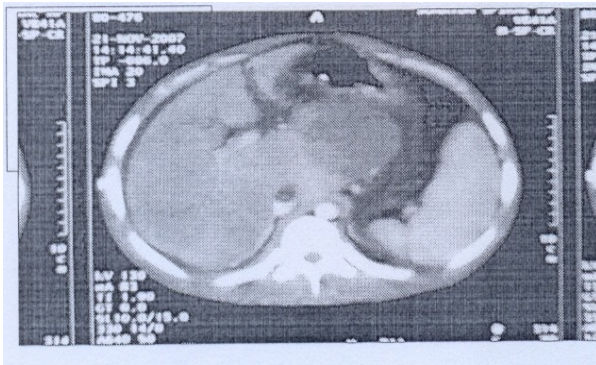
Budd shiari syndrome patient with thrombus and generalized reduction in hepatic parenchymal echogenicity on post contrast enhanced CT
